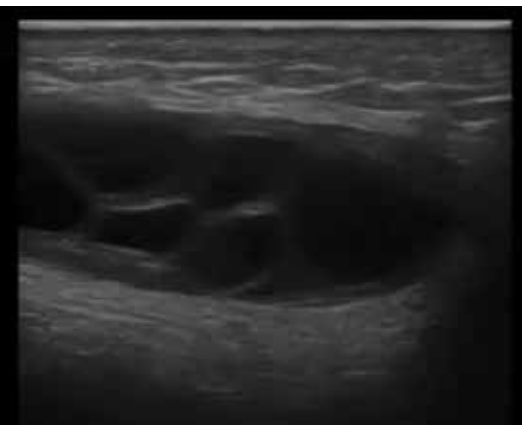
Mass found on ultrasound
